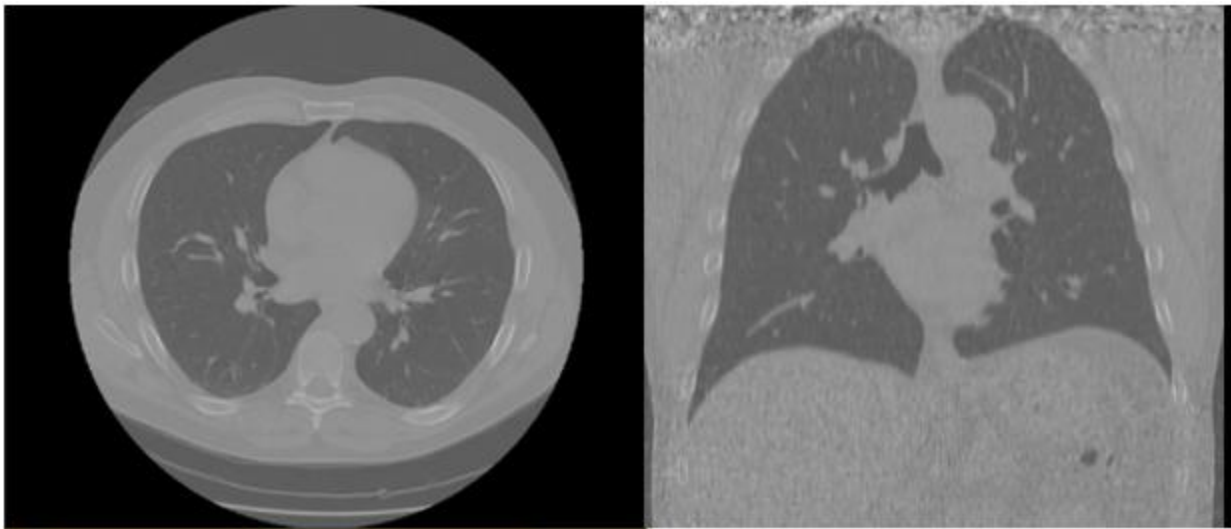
MRI scans of tuberculosis infected lung (A) axial view) and (B) coronal view*
